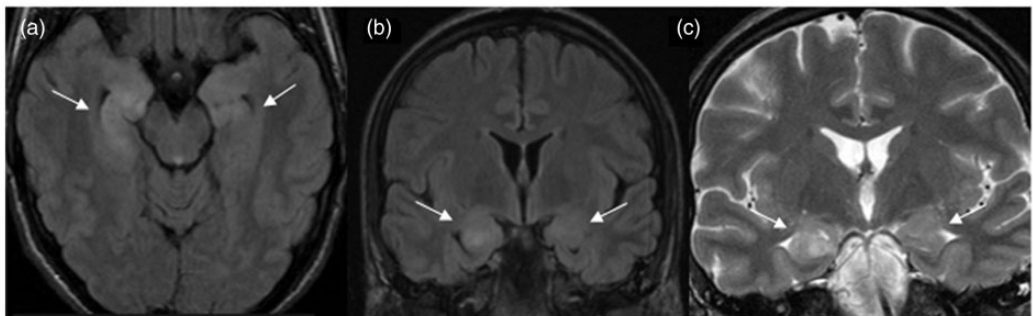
Magnetic resonance images of a 28-year-old male patient that was admitted to the emergency department with complaints of hypothermia, temporal disorientation, confusion, psychomotor agitation and generalized tonic-clonic seizures: (a) axial fluid-attenuated inversion recovery (FLAIR) image; (b) coronal FLAIR image; (c) coronal TSE-T2 weighted image. The images show high hippocampal and amygdala volume and signal intensity (arrows).
